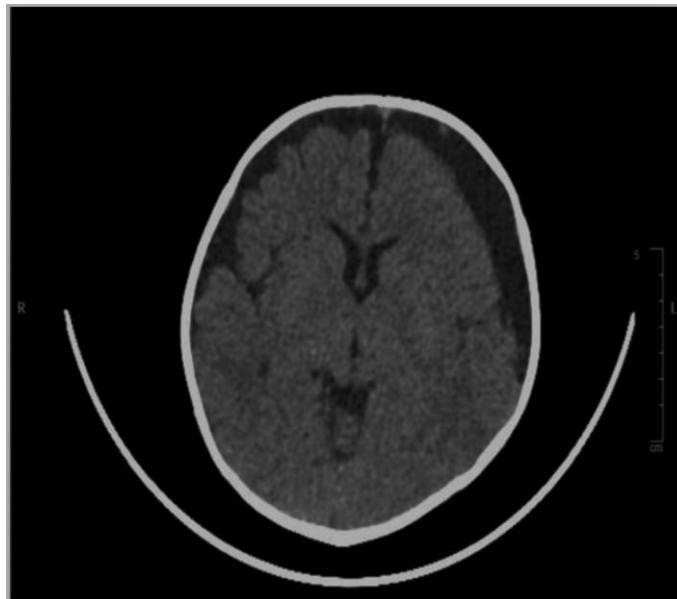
CT brain study done before burr hole procedure to check if there is increase in size of the hygroma.
